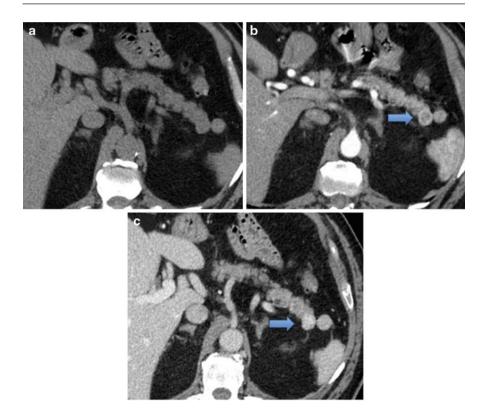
Computed tomography (CT) of the pancreas. The pancreas is presented without contrast media (a), during the arterial (b) and venous phases (c). Note the presence of a lesion (*arrow*) presenting an enhancement at the arterial and venous phase (wash-in), corresponding to an insulinoma. The native islets cannot be resolved with CT
